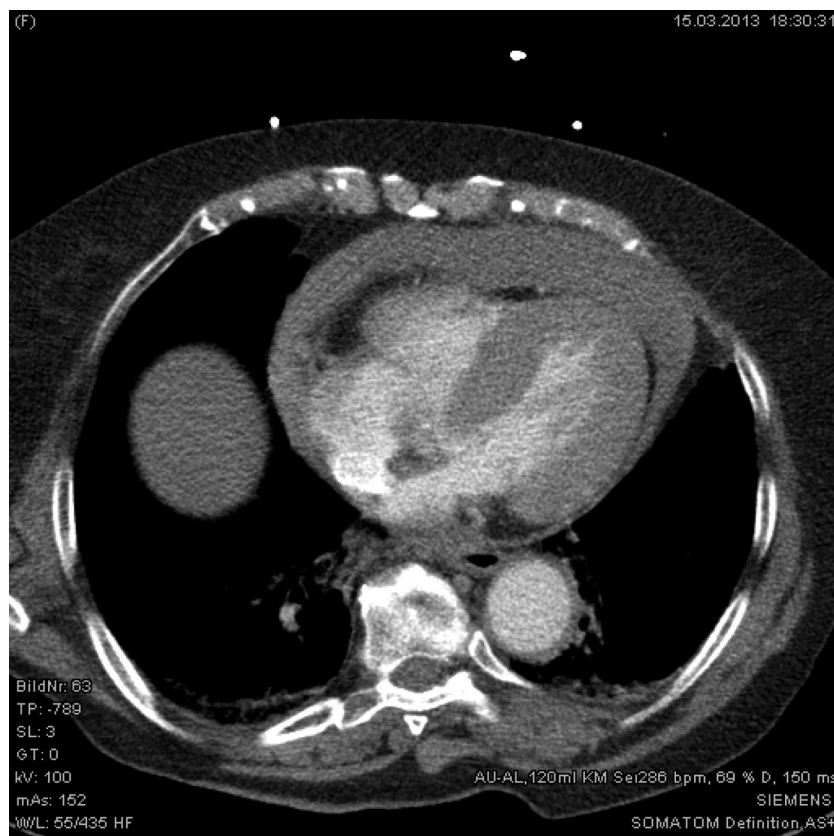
CT scan of the dissection membrane limited to the ascending aorta.
